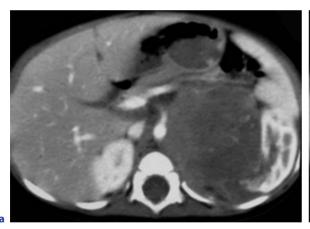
Adrenal neuroblastoma in a 10-month-old boy invading the upper pole of left kidney. a On unenhanced transverse CT scan the mass is almost totally extra-renal; on enhanced scan (b) the renal artery (*arrow*) is encased by the tumor. These features are suggestive of neuroblastoma and rarely observed in WT
